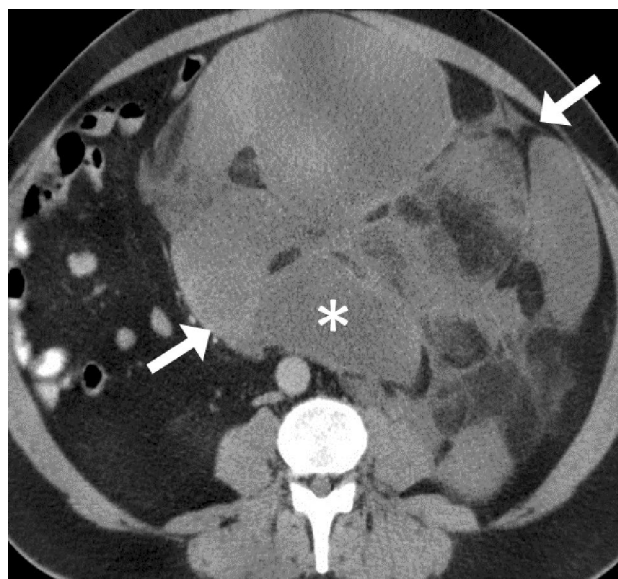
Myxoid liposarcoma. Contrast-enhanced CT in the portal venous phase shows a mass (arrows) with mixed fat and soft tissue attenuation, including several fluid attenuating components (asterisk) corresponding to the myxoid components within a liposarcoma
